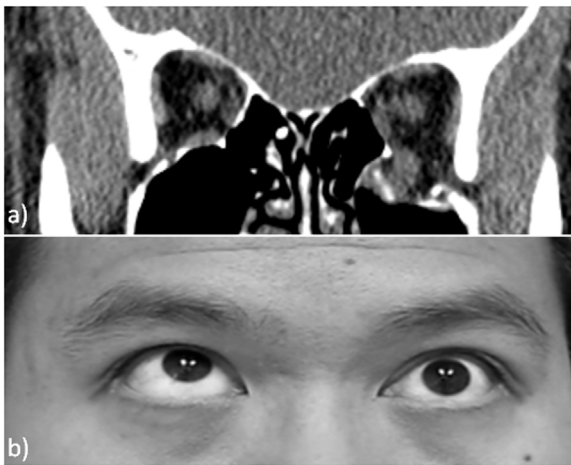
CT scan (a) of a patient with BOF in left orbit with limitation to elevate the left eye, remaining 13 days after the injury (b). This patient was considered to have impingement of left inferior rectus muscle.
